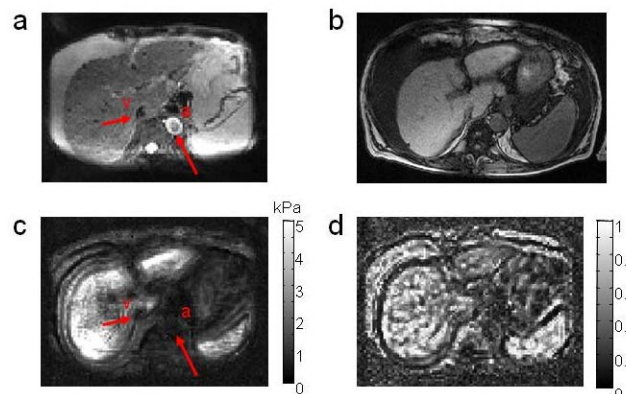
Slice from a 3D-MRE data set of patient with portal hypertension, ascites and fibrosis. Magnitude of the MRE signal (a), T1-weighted anatomical image (b), $|G^*|$ (c) and α (d). Inferior vena cava and descending aorta are pointed by arrows, labeled with "v" and "a", respectively.
